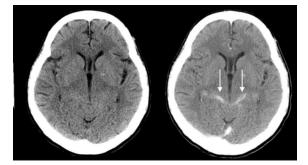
A 25-year-old patient was diagnosed tuberculous meningitis by CT due to leptomeningeal enhancement at bilateral basal cisterns (arrows). However, final was proved by CSF culture and positive india ink for cryptococcosis
